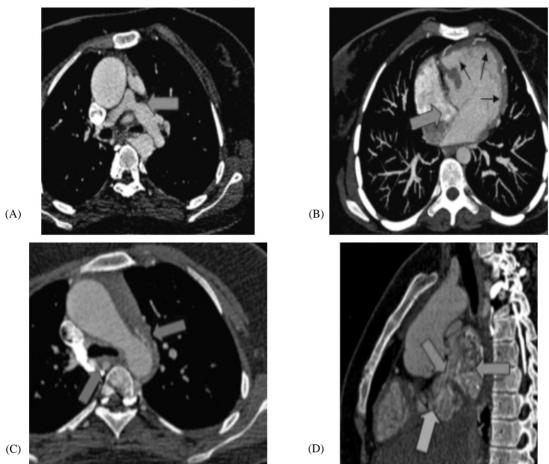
(A) Axial MDCT images showing main pulmonary trunk and brancheshypoplasia (white arrow). (B) Axial image showing TV atresia (arrow) and single left ventricle (small black arrows). (C) Multiple MAPCAs (arrows). (D) Sagittal reconstructed CT image showing ASD (red arrow) between the RA (arrow) and LA (arrow).
